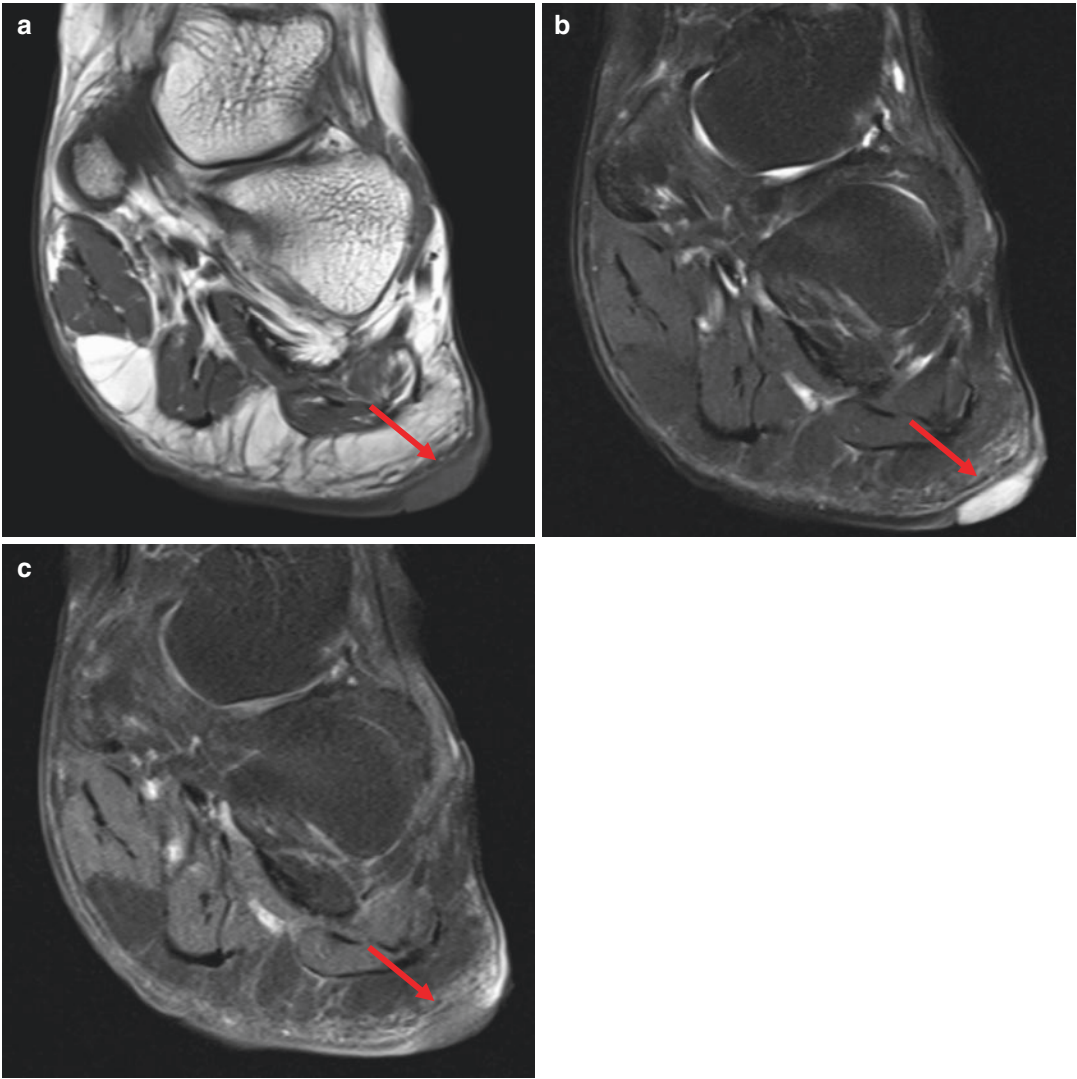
Malignant melanoma. On MR imaging, a fungating skin lesion (*arrows*) is observed on the lateral aspect of the sole at the level of the calcaneocuboidal joint. The mass exhibits hyperintensity on both T1WI (a)
